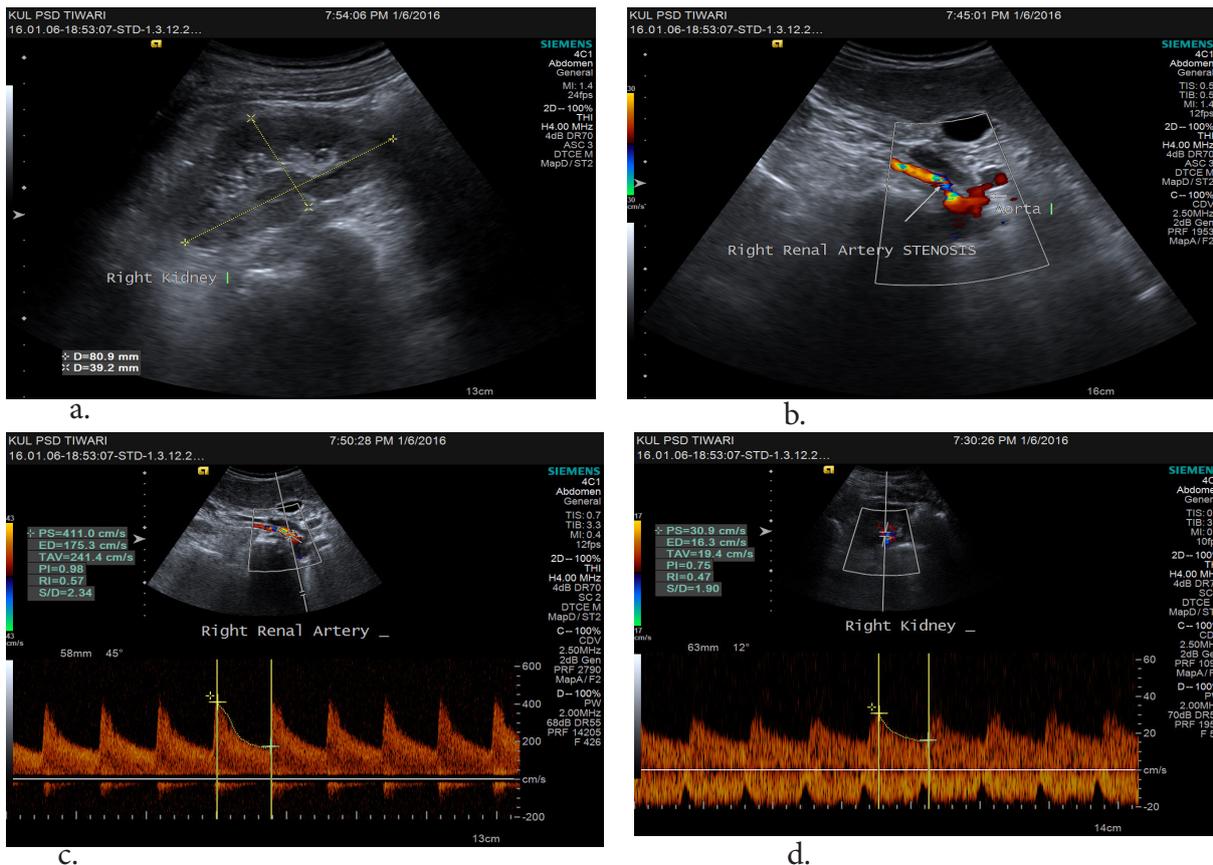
Ultrasound and Doppler images of 56 year old hypertensive patient showing right renal artery stenosis. a. Ultrasound image shows small size of right kidney. b. Color Doppler shows turbulent flow at the proximal segment of right renal artery (arrow). c. Spectral Doppler shows high velocity of 411.0 cm/sec in right renal artery suggestive of significant stenosis. d. Intrarenal interlobar artery shows low resistant flow with resistance index of 0.47.
